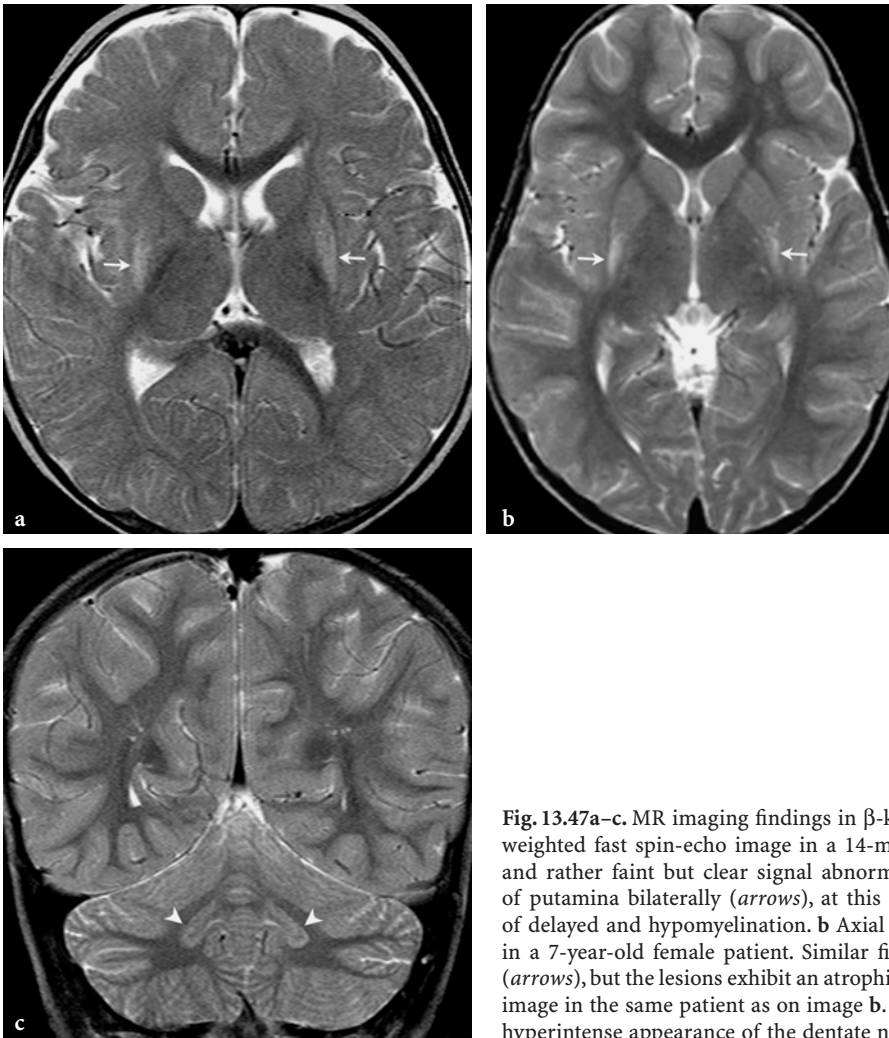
MR imaging findings in β -ketothiolase deficiency. a Axial T2-weighted fast spin-echo image in a 14-month-old male patient. Ill-defined and rather faint but clear signal abnormalities within the posterior parts of putamina bilaterally (*arrows*), at this stage without atrophy. Suggestion of delayed and hypomyelination. b Axial T2-weighted fast spin-echo image in a 7-year-old female patient. Similar findings as in the previous patient (*arrows*), but the lesions exhibit an atrophic character. c Coronal T2-weighted image in the same patient as on image b. Somewhat atrophic and abnormal hyperintense appearance of the dentate nuclei (*arrowheads*)
